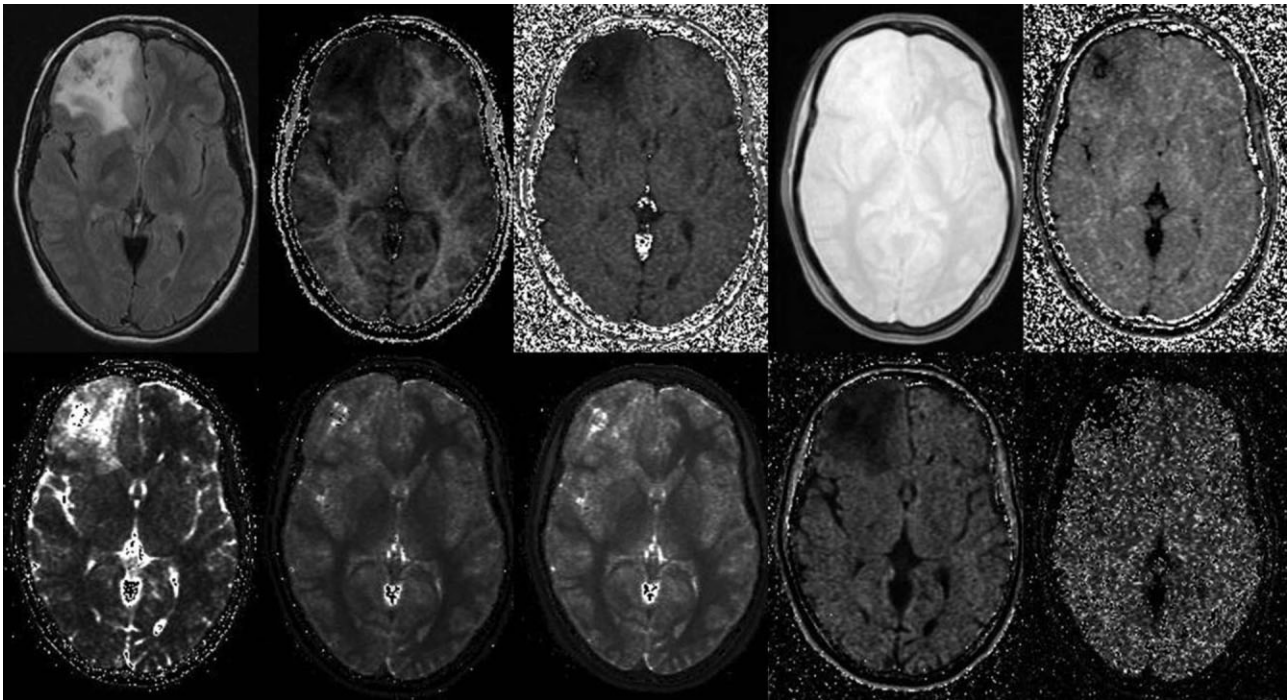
Images and parameter maps for a subject with an anaplastic oligodendroglioma. The images are (from left to right, top then bottom row): fluid attenuation inverse recovery (FLAIR) image (fast spin echo FLAIR image, axial plane, TR/TI/TE = 8774/2192/161 ms), f_B , $f/R_A(1 - f_B)$, gM_0^A , T_{2B} , T_{2A} , T_{1A} , T_{1obs} , $1/R_A T_{2A}$ and RM_0^A (all calculated parameter maps in the axial plane). The tumour is visible in the top left corner of the brain (as viewed), and most parameters show abnormalities in the tumour and heterogeneity within it.
